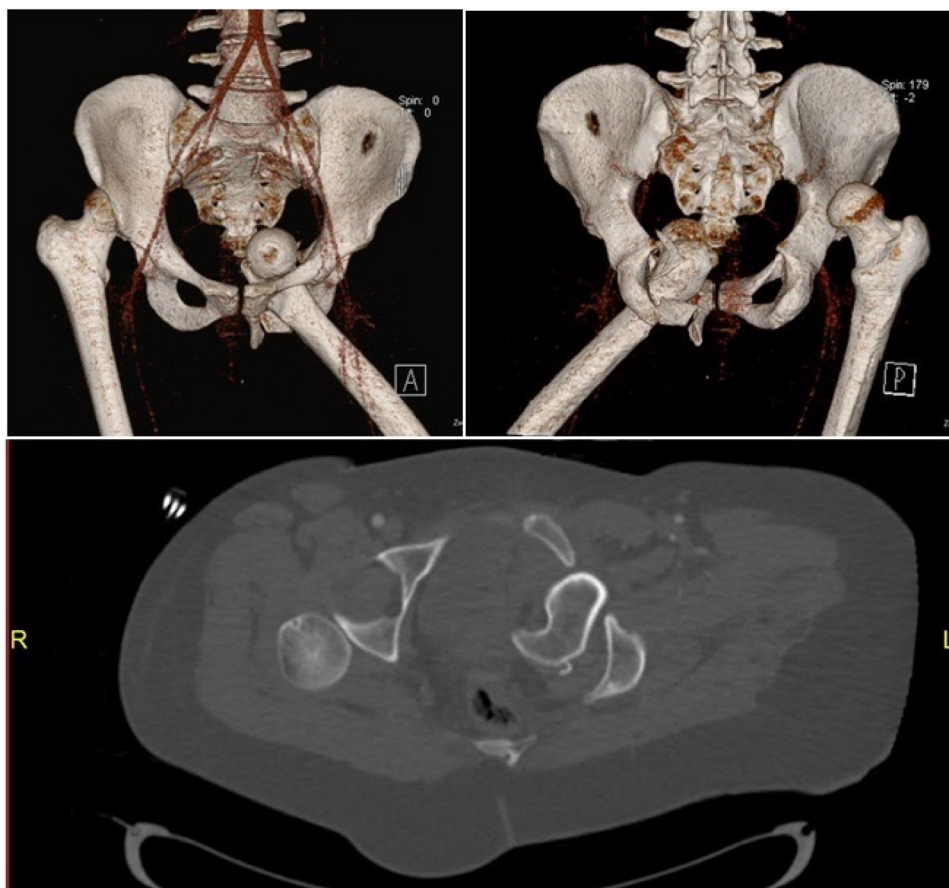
pre-reduction 3D reconstructive CT Images and axial cuts.
